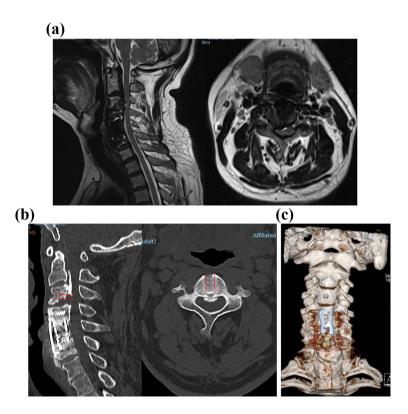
Radiological images at 3 months after the second operation. (a) Sagittal and axial magnetic resonance imaging images; (b) Sagittal and axial computed tomography (CT) image (red mark: bony channel); (c) 3-dimensional reconstruction of the cervical spine
